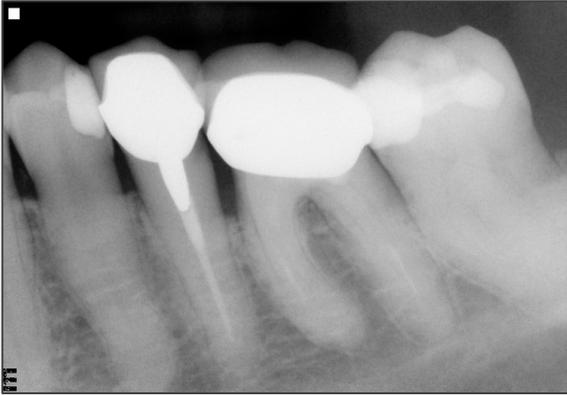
Tooth #19 (36) successfully filled with Biocalex, but it is invisible on x-ray.
